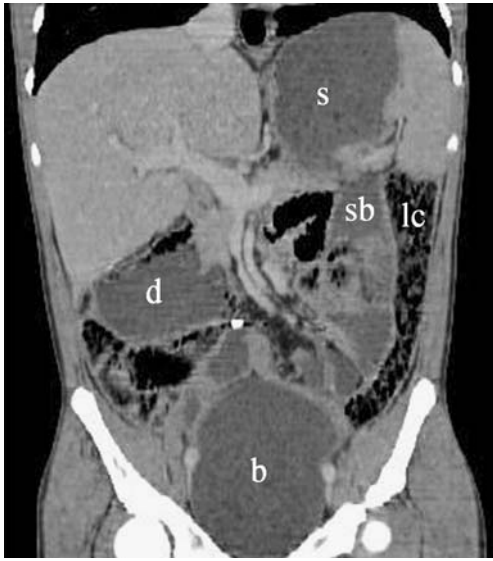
A 19-year-old man with a known myogenic form of CIPO and prior history of ileostomy. The patient presented with abdominal pain and vomiting. Coronal CT reformation of MDCT shows marked dilatation of the stomach (s), duodenum (d), small bowel loops (sb) and left colon (lc) and excluded actual bowel obstruction. The patient was managed with conservative therapy. Distension of the bladder (megacystis) (b) is detected as a complication of the disease
